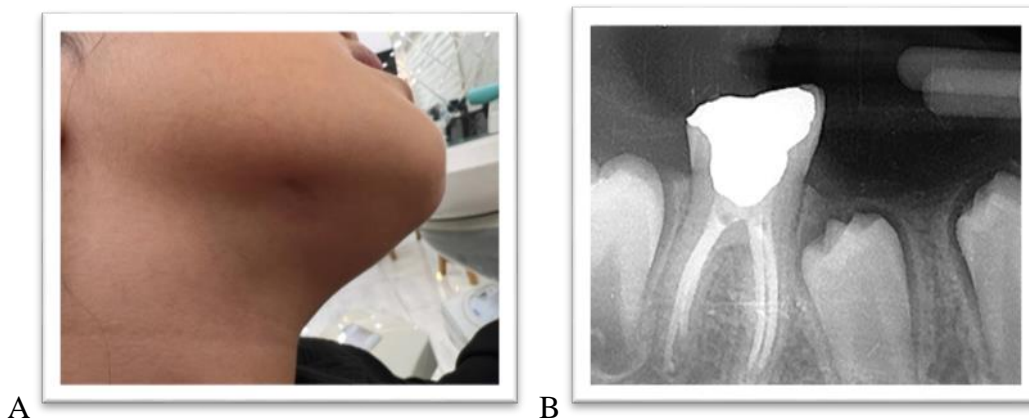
Clinical appearance (A) and PA radiograph (B) after one year follow up.
